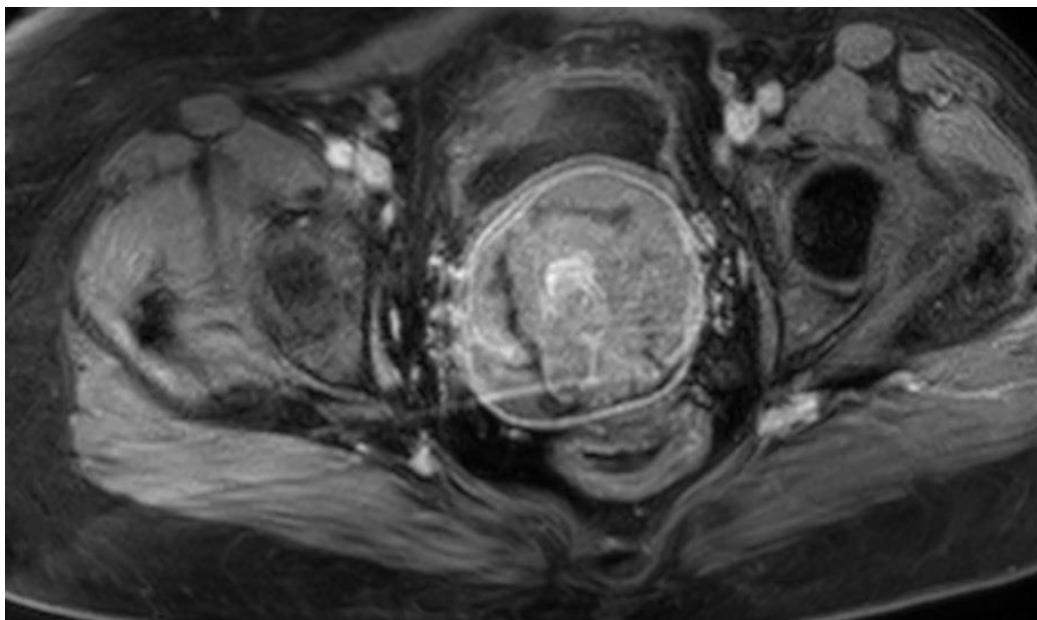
Axial contrast-enhanced MRI sequence demonstrating a cervical mass with heterogeneous enhancement (Case 2).
